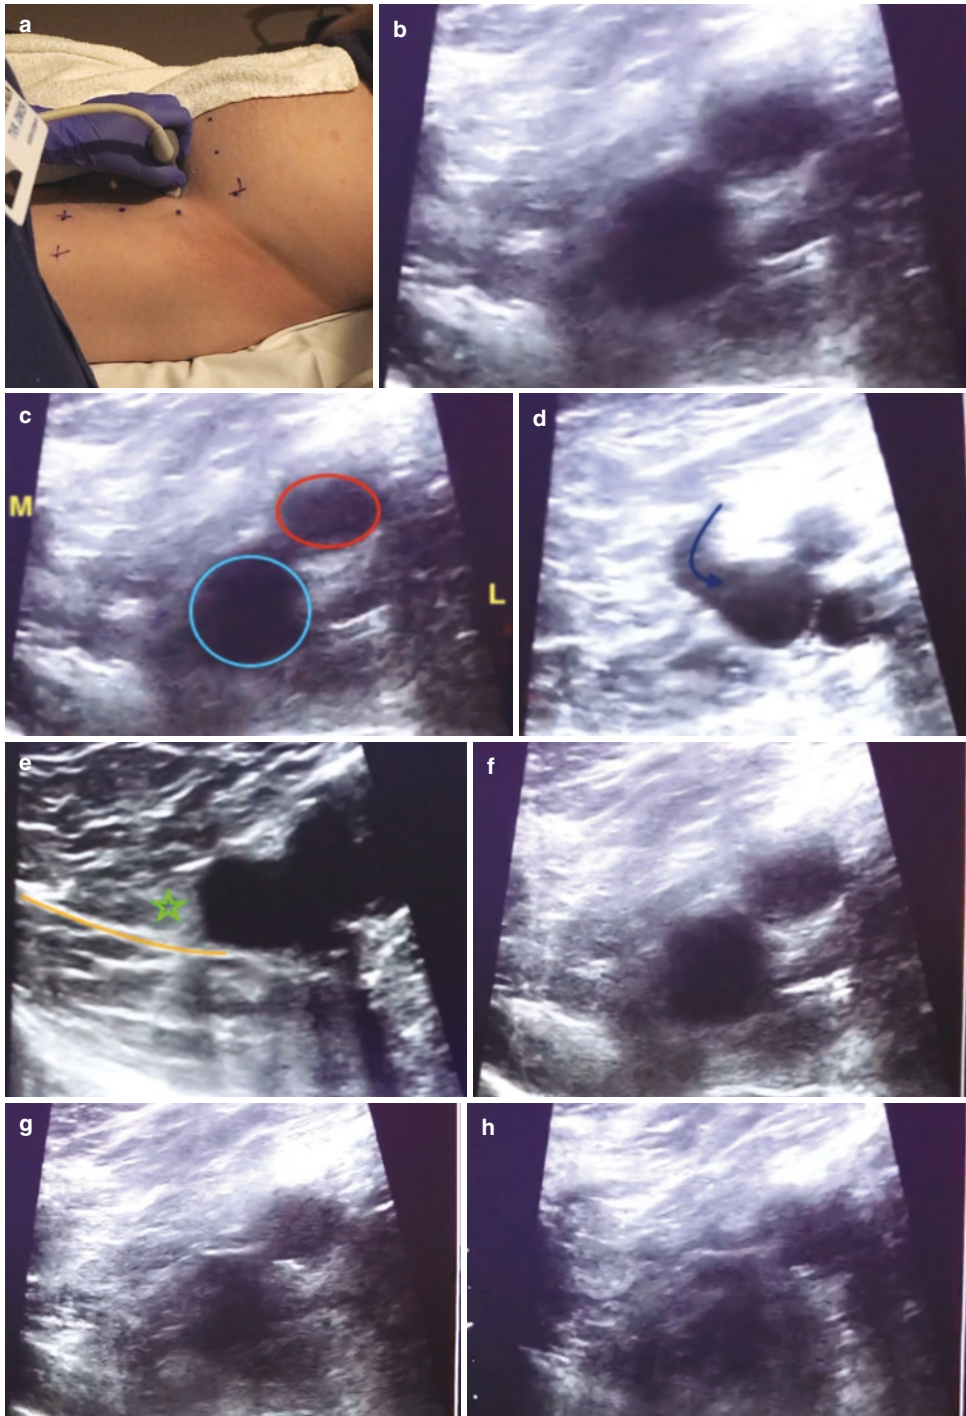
Dynamic ultrasound to identify a femoral hernia. (a) The patient is supine with their leg straight and the ultrasound probe is held in the transverse position to obtain a cross-section of the femoral vessels. (b, c) Cross-section of the femoral vessels—for orientation medial and lateral (M & L) are marked. The femoral vein is marked in blue and the femoral artery is marked in red. (d) The
